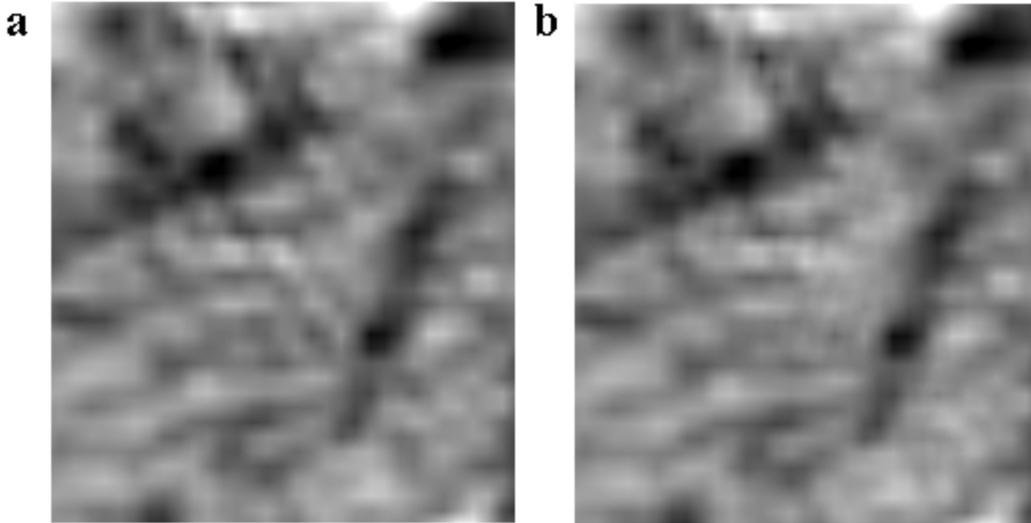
(a) A single cropped section of the contrast CT scans showing a directional component of the beam-hardening artifact caused by the biliary stent. (b) The same cropped section of the contrast CT scan after the artifact removal algorithm has been applied to the image.
